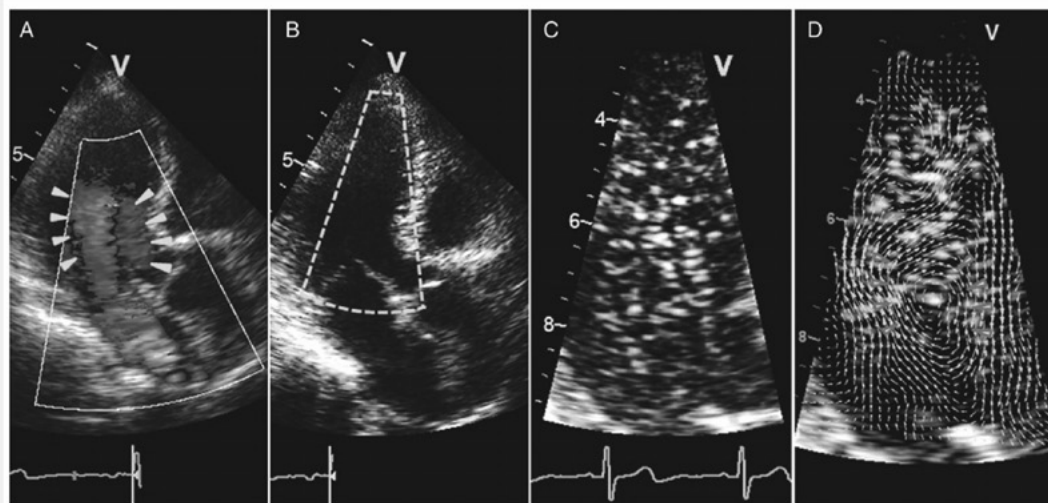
Echocardiographic-contrast particle imaging velocimetry. (A) Colour Doppler imaging showing the bidirectional flow during early diastole. (B) Delineation of the region of interest in the submitral and LV outflow region. (C) High-temporal resolution contrast echocardiography is performed for the region of interest. (D) Contrast particle imaging velocimetry shows the flow field with velocity vectors. Note the presence of a CW vortex (arrows).
